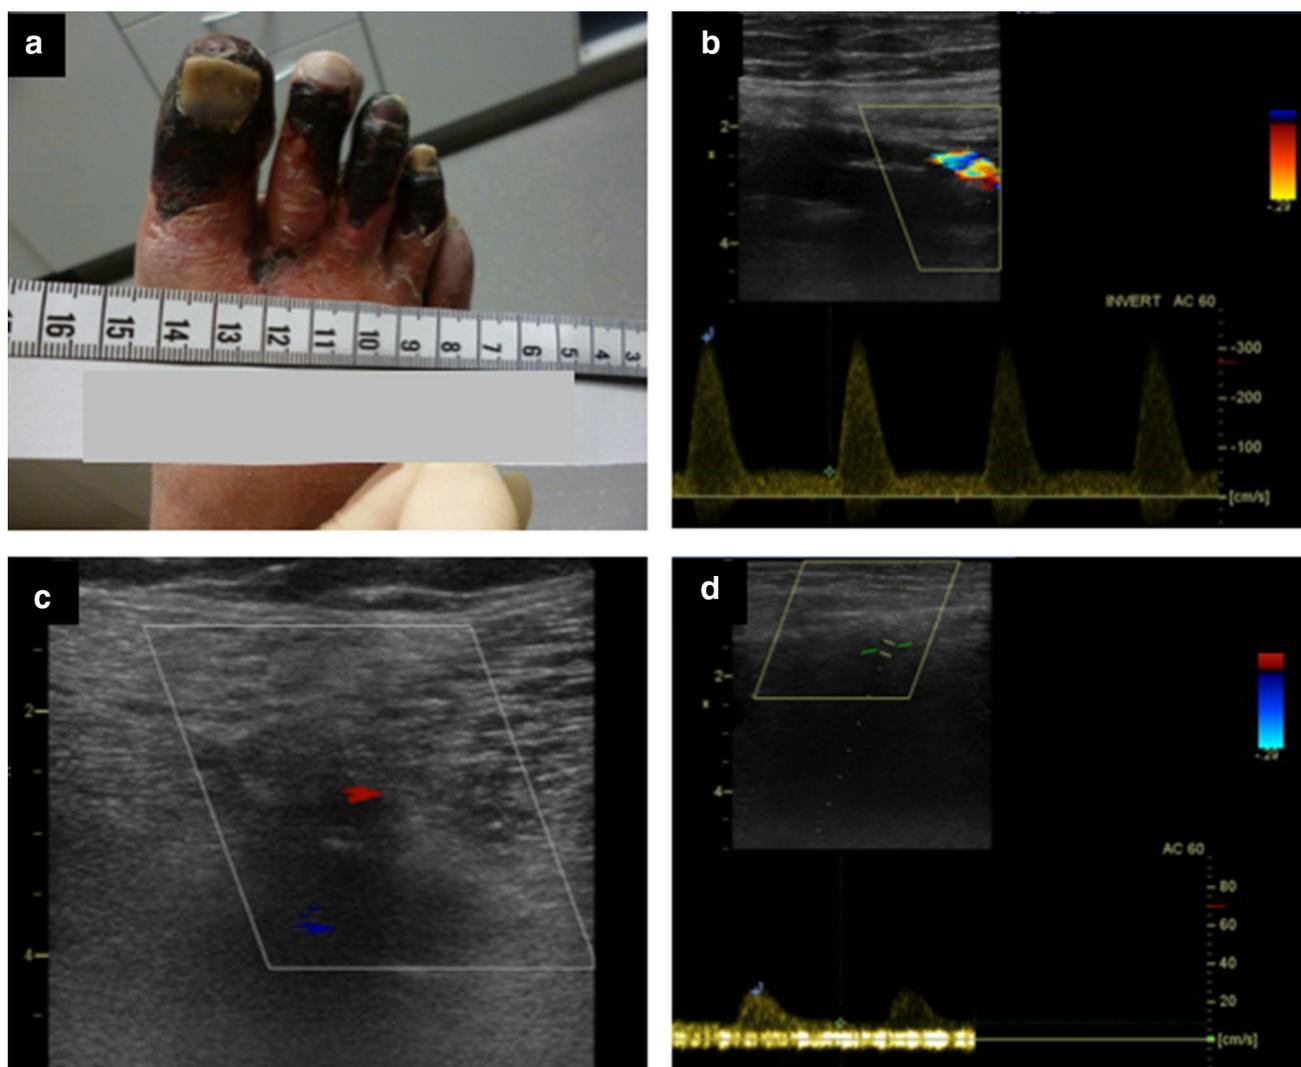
Clinical and Doppler sonography acquisitions. a Clinical image at admission. Note the wet gangrene of toes I–V. b Doppler sonography in the distal superficial femoral artery. Note the significantly increased peak systolic velocity, indicative of significant stenosis. c Transverse acquisition at the same level. Note the significantly reduced arterial lumen suggesting subtotal occlusion. d Doppler sonography in the distal segment of the posterior tibial artery. Note the presence of a blunted monophasic flow profile
